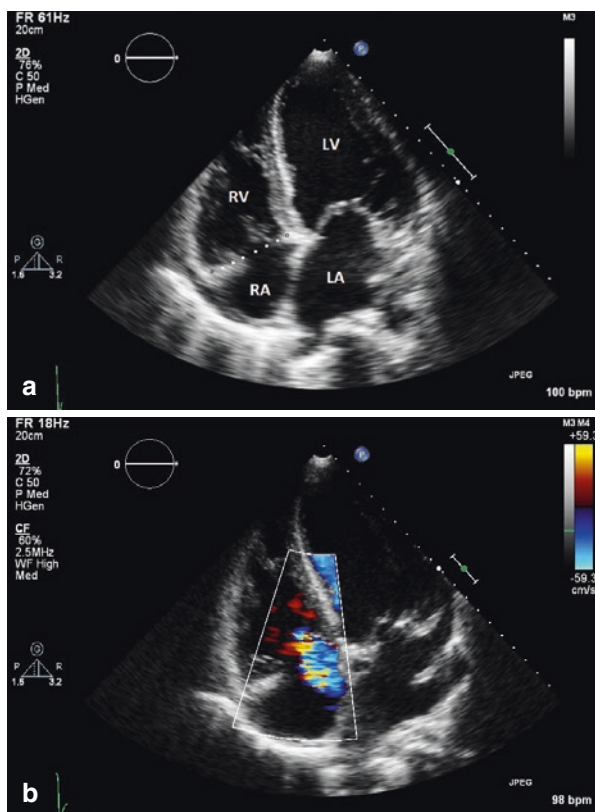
(a) TTE 4-chamber view, note the left sided dilatation. The tricuspid annulus measured 48 mm. (b) TTE Doppler of the tricuspid valve demonstrated severe insufficiency. Note the direction of the jet points toward the atrial septum (eccentric jet). *RA* right atrium, *RV* right ventricle, *LV* left ventricle, *LA* left atrium
